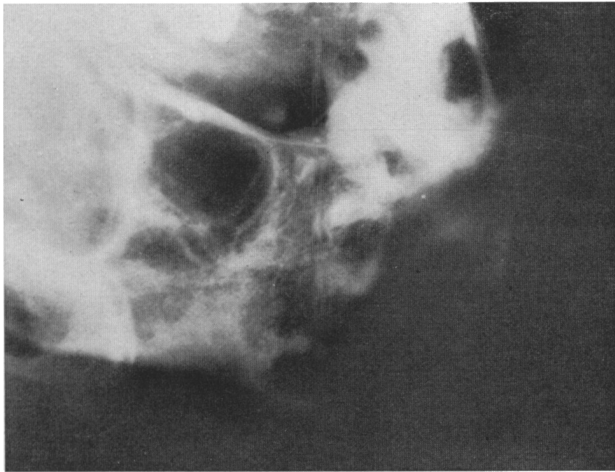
Radiograph taken from VI-11 before the cosmetic operation. Notice the large cavities and the differences in bone density
